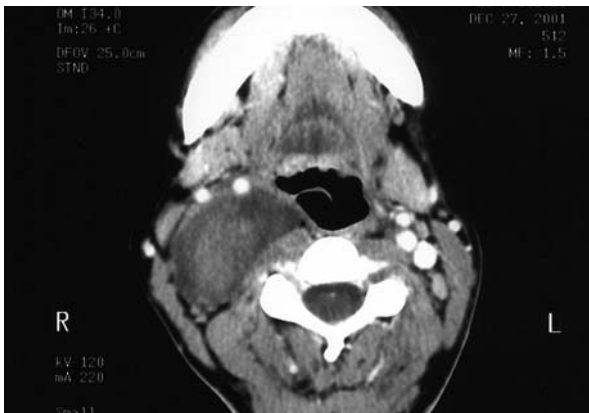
CT findings. CT scans showing a well-circumscribed mass with soft tissue density. Anterior displacement of the carotid artery and internal jugular vein was noted.
